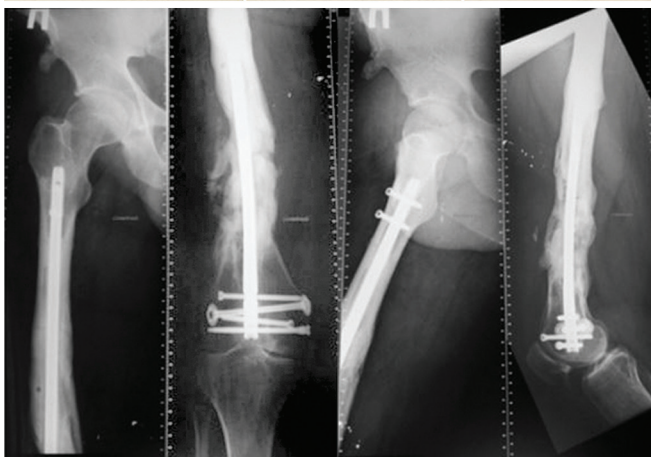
Anatomofunctional and radiographic outcome after 2 years
